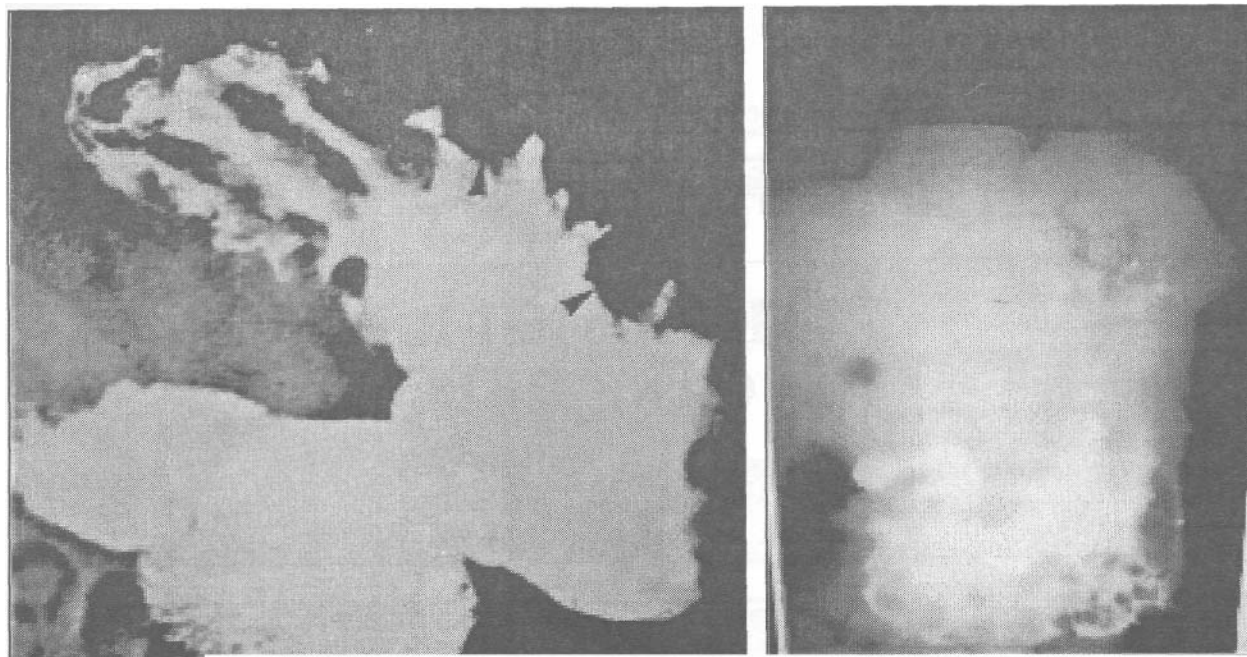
An x-ray of the gastro duodenum of different patients with Ménétrier disease
